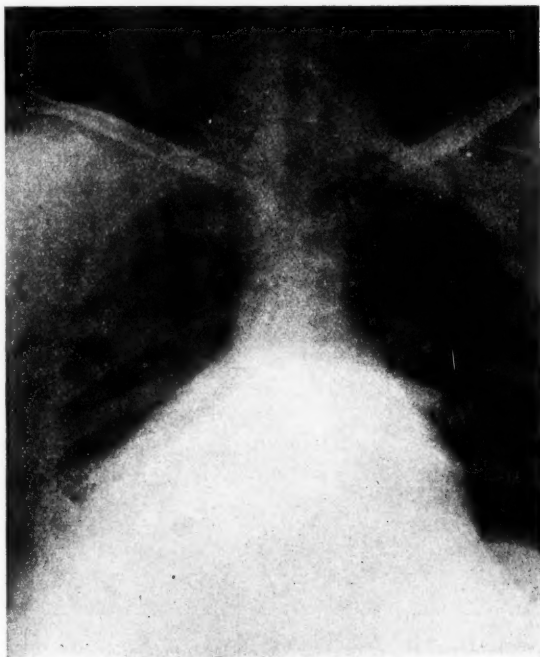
Case II. Roentgenogram taken on admission to the medical ward. Large pericardial effusion. Note the acute cardiohepatic angle.
